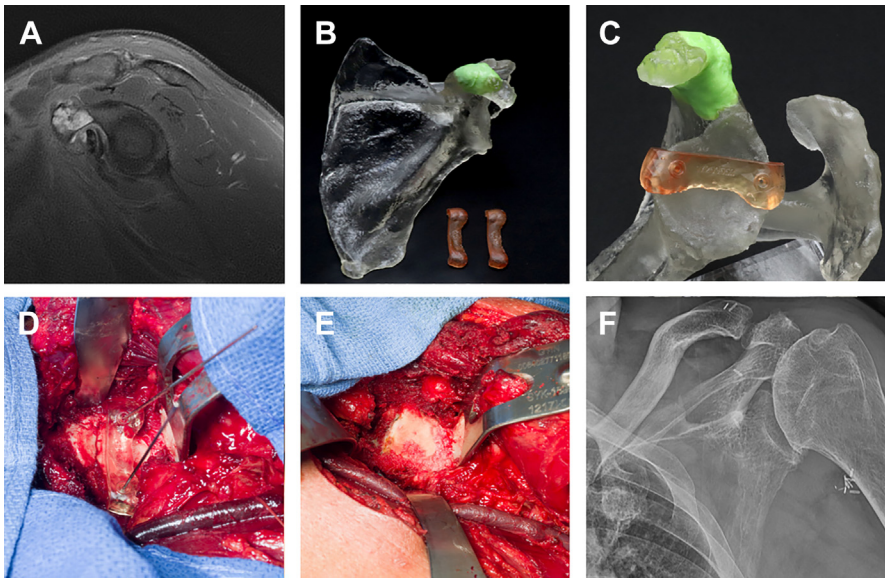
Sagittal T2 (A) MRI showing a low-grade chondrosarcoma involving the coracoid. In order to reduce the size of resection, a 3-dimensional model and patient-specific guides were fabricated (B) to allow for an osteotomy of the coracoid from the glenoid (C). The guide was placed intraoperatively (D), and the cut (E) allowed for a negative margin excision and preservation of most of the glenoid (F).
